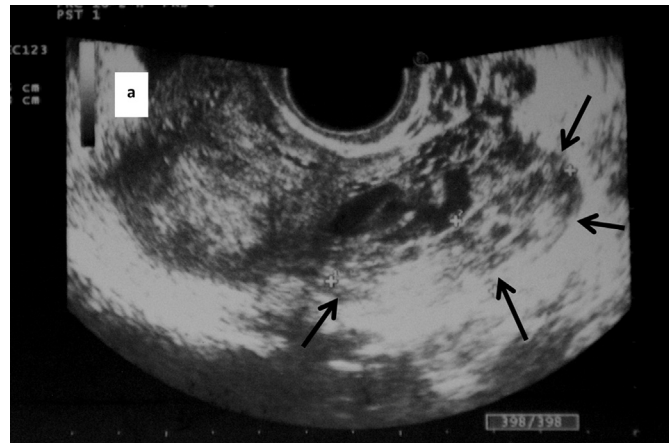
Transvaginal sonography: heterogenous left latero uterine mass, which is 43.4 mm × 42.3 mm in size (arrow).
